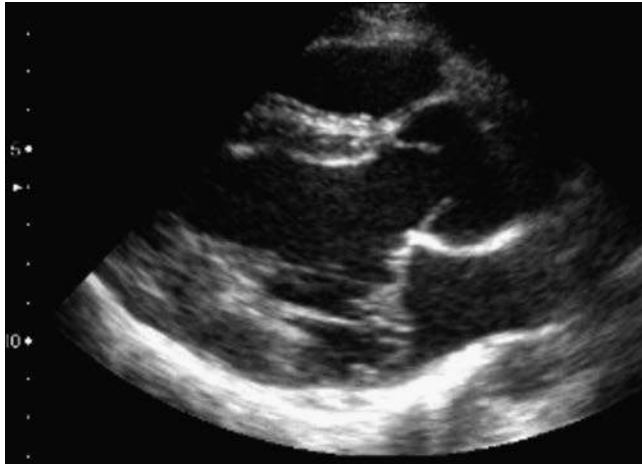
Prolapse of the posterior leaflet of the mitral valve. The echocardiographic criteria for classic MVP are a dislocation more than 2 mm to the left atrium of a least one of the mitral valve leaflets during systole, and a thickening of 5 mm or more of the prolapsing valve leaflet during diastole. A hypothetical line through the insertion points of the anterior and posterior mitral valve leaflet refers dislocation.
